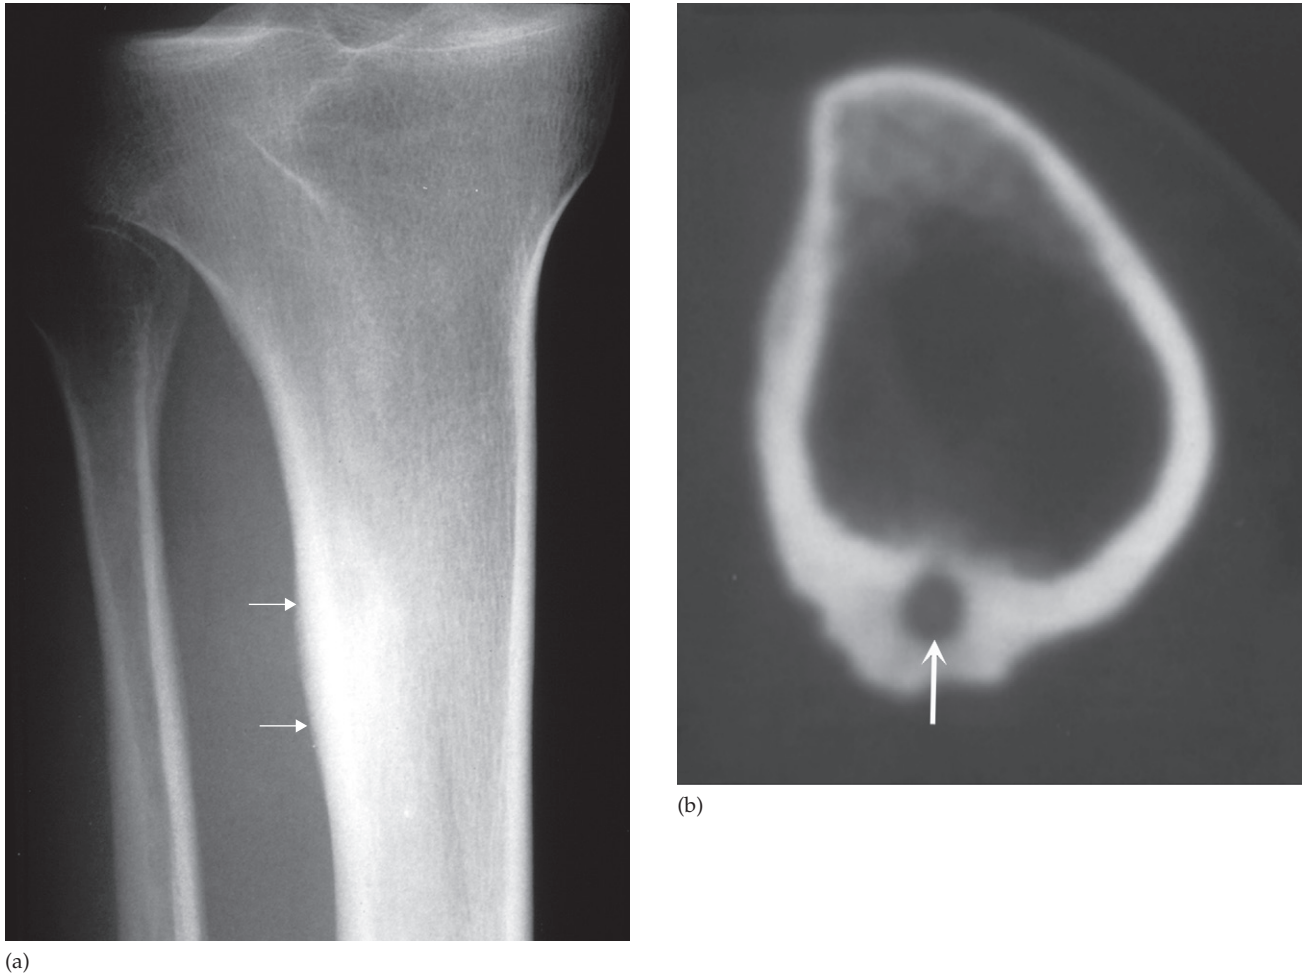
Osteoid osteoma. (a) Plain film showing an area of sclerosis at the upper end of the tibia (arrows). (b) CT scan showing sclerosis with a central lucency known as a nidus (arrow).
